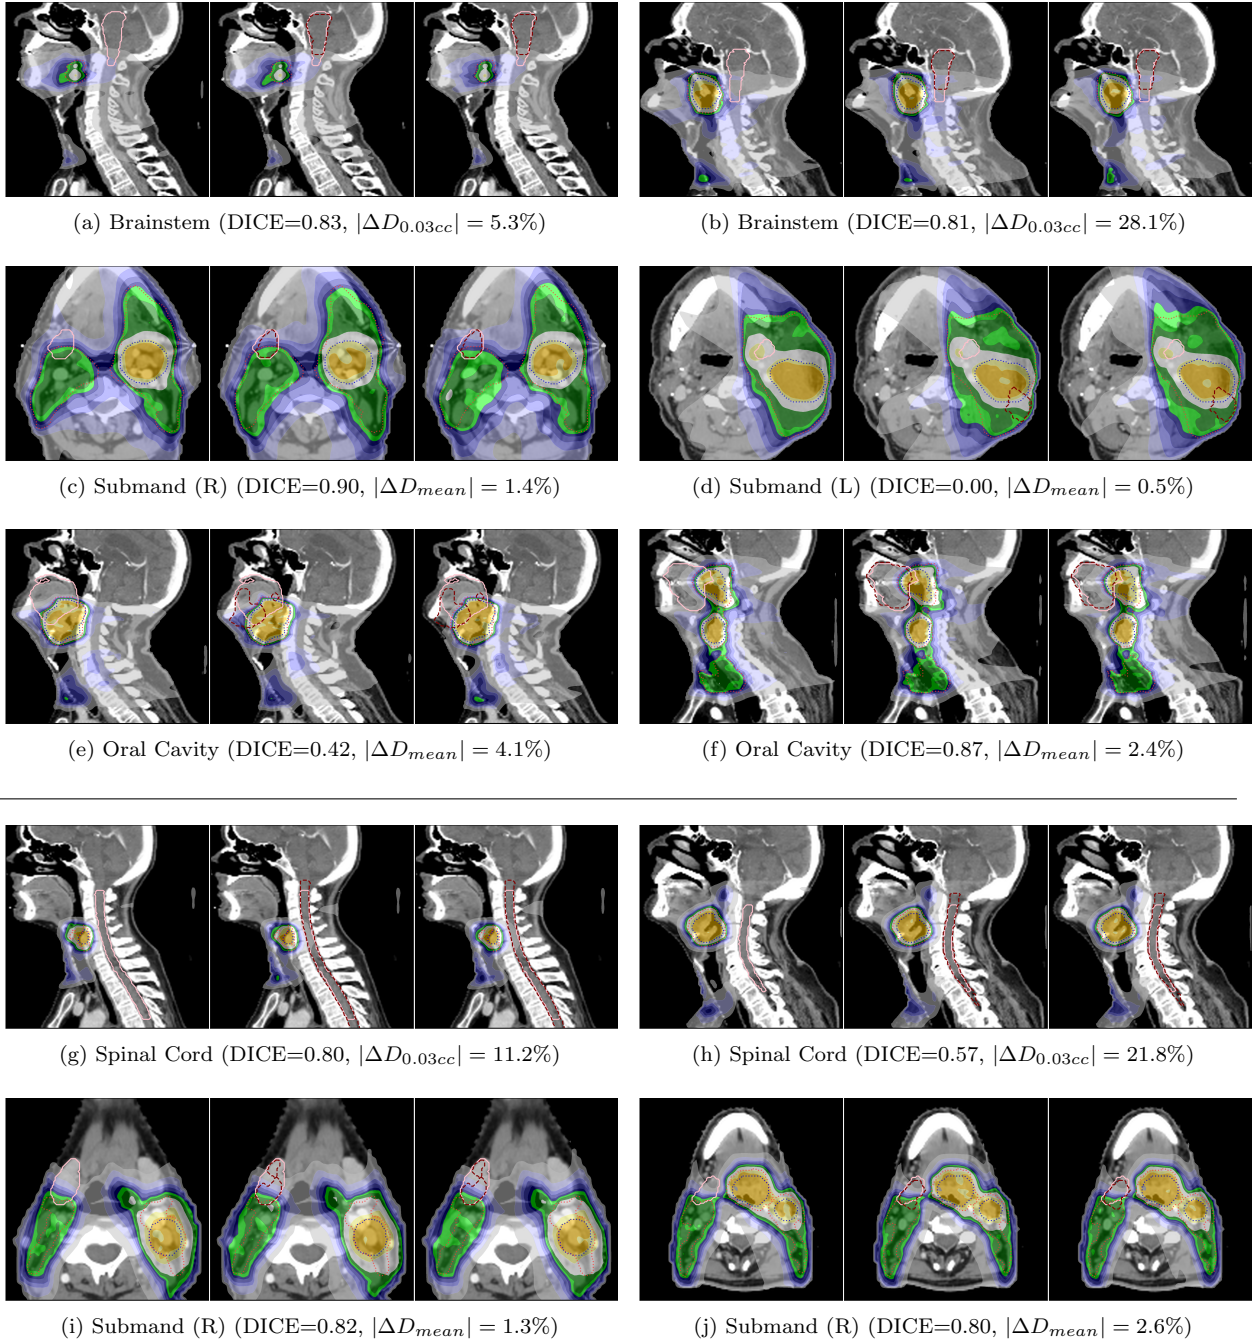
This figure shows CT scans of photon (a-f) and proton (g-j) patients overlaid with a dose distribution as well as PTV (DL1) (orange), PTV (DL2) (blue), manual (pink) and automated (maroon) contours. Each example shows the P_{OG} , P_{MC} and P_{AC} plans from left to right. The dose metric in the sub-captions compares the absolute percentage difference of $P_{MC} - P_{AC}$.
